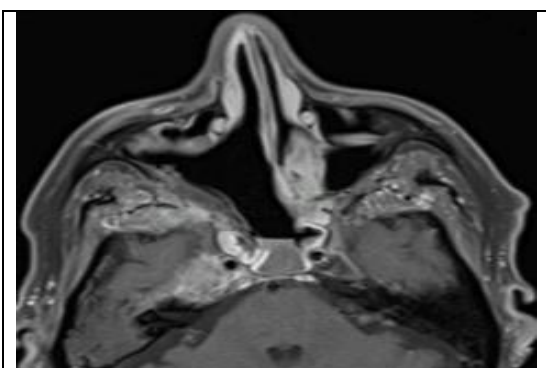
Right cavernous sinus involvement with disease surrounding the right internal carotid artery as shown on a postoperative magnetic resonance imaging scan.
